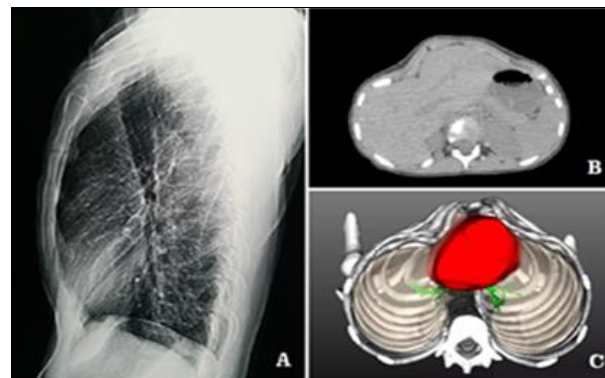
Imaging examination of saddle chest. A, X-ray lateral image; B, CT section image; C, 3D reconstruction image.
